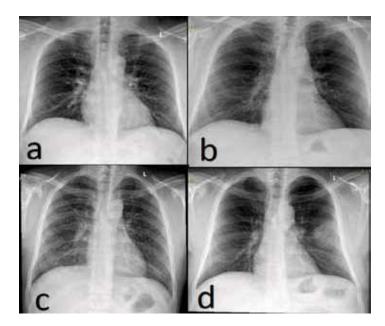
Plain Chest x-ray postero-anterior views in four patients (a) showing bilateral macro and micro-nodular infiltration (2/2 ILO profusion grade, p/p size) with increase broncho-vascular marking and calcified hilar lymph node. (b) showing right macro and micro-nodular infiltration (1/1 ILO profusion grade, t size) with minor bilateral basal reticular and left basal atelectasis.(c) showing bilateral macro and micro-nodular infiltration (2/2 ILO profusion grade, p/q size) with ground glass appearance of interstitial lung disease (e) showing calcified/healed granulomatous process of pneumonia in left lobe and calcified hilar lymph nodes.
